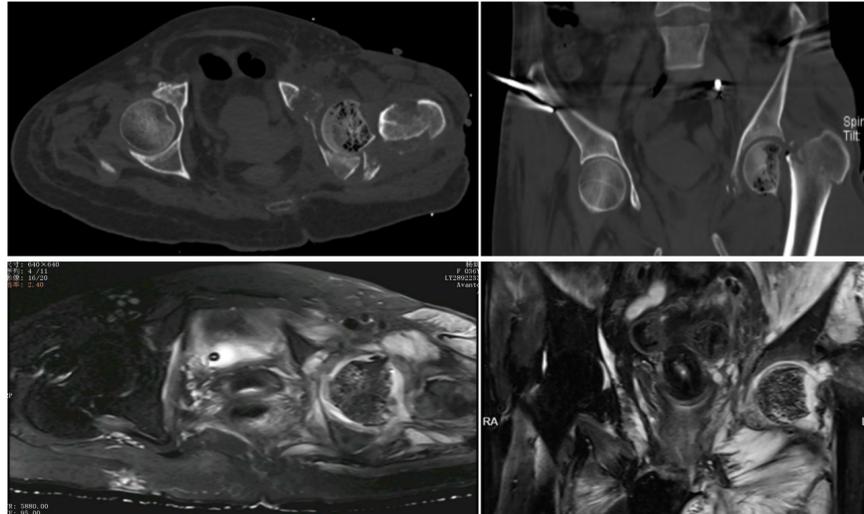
100 days after injury, pelvic CT and MRI showed necrosis of the left femoral head. A. CT's axial and coronal sections. B. MRI's axial and coronal sections.
